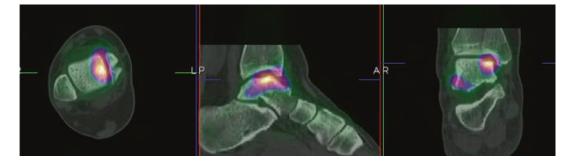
SPECT of the same patient in Fig. 1 showing bone activity in the osteochondral lesion
